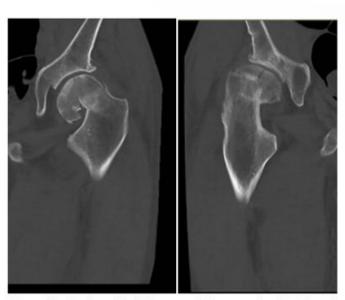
(Left to right) Computed Tomography (CT) imaging of the left and right hip respectively demonstrating bilateral impacted neck of femur fractures.
